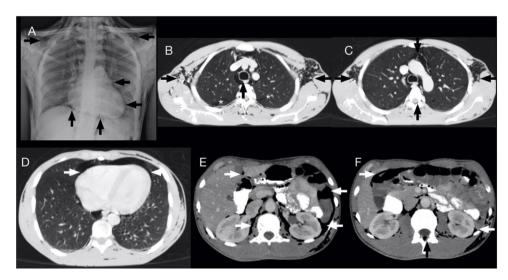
Fifteen-year-old male, arrived on small boat, admitted for necrotising fasciitis of the right ankle. Chest radiograph performed by protocol showing accidental finding of subcutaneous emphysema, pneumomediastinum and pneumoperitoneum (A). Chest CT in lung window confirms the Macklin effect with linear collections of air dissecting the bronchovascular sheath (white asterisks) in both upper lobes (B), associated with subcutaneous emphysema and pneumomediastinum (B and C), pneumorrhachis (black arrows) (C) and pneumopericardium (white arrows) (D). CT of the abdomen in soft tissue window showing pneumoperitoneum and retropneumoperitoneum (white arrows) (E and F), confirming the presence of pneumorrhachis (black arrow) at several levels (black arrow) (F).
